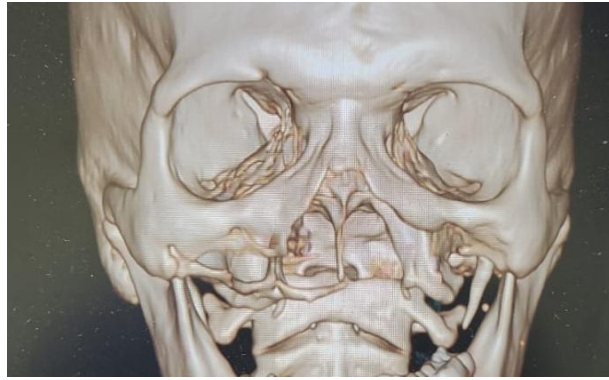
Pre operative CBCT image of Atrophic Maxilla
